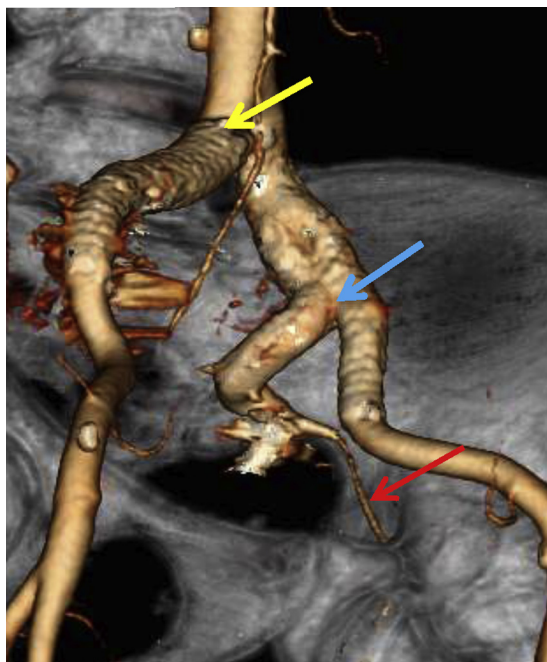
A three-dimensional reconstruction of a computed tomography angiogram at the 1-month follow-up visit after elective repair of left hypogastric iliac artery aneurysm repair shows good positioning of grafts in the right and left iliac arteries. The branched device can be seen on the left side with inclusion of hypogastric and external iliac artery (red arrow). The patent gluteal artery on left side can also be seen as well (blue arrow). The GORE EXCLUDER (W. L. Gore and Associates, Flagstaff, Ariz) iliac limb (yellow arrow) is seen in the right common and external iliac artery.
